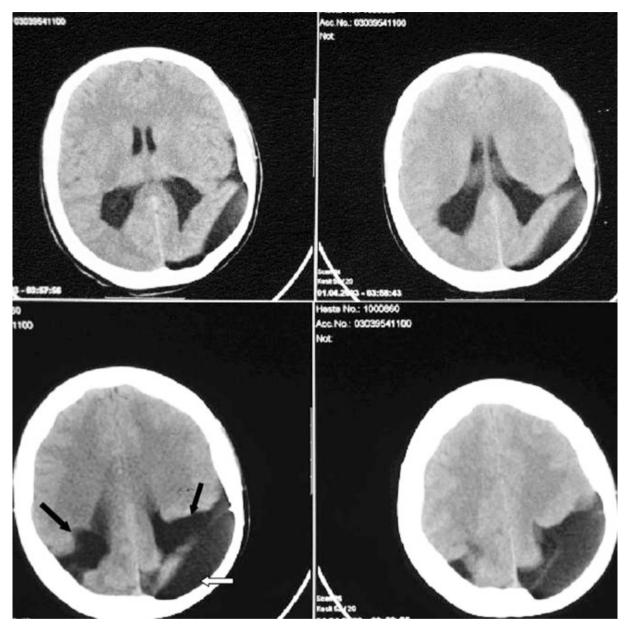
Serial axial CT images of the patient show bilateral separated lip schizencephaly and chronic subdural fluid collection overlying left cleft of schizencephaly at the parieto-occipital region. Black arrows point clefts and white arrow points subdural collection.
